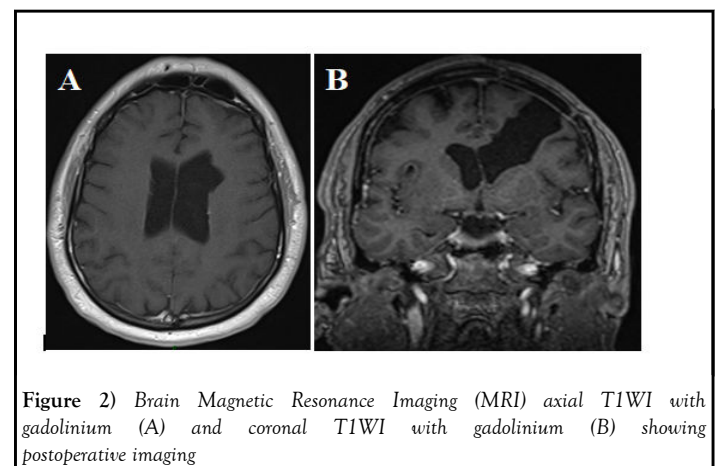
Brain Magnetic Resonance Imaging (MRI) axial T1WI with gadolinium (A) and coronal T1WI with gadolinium (B) showing postoperative imaging
